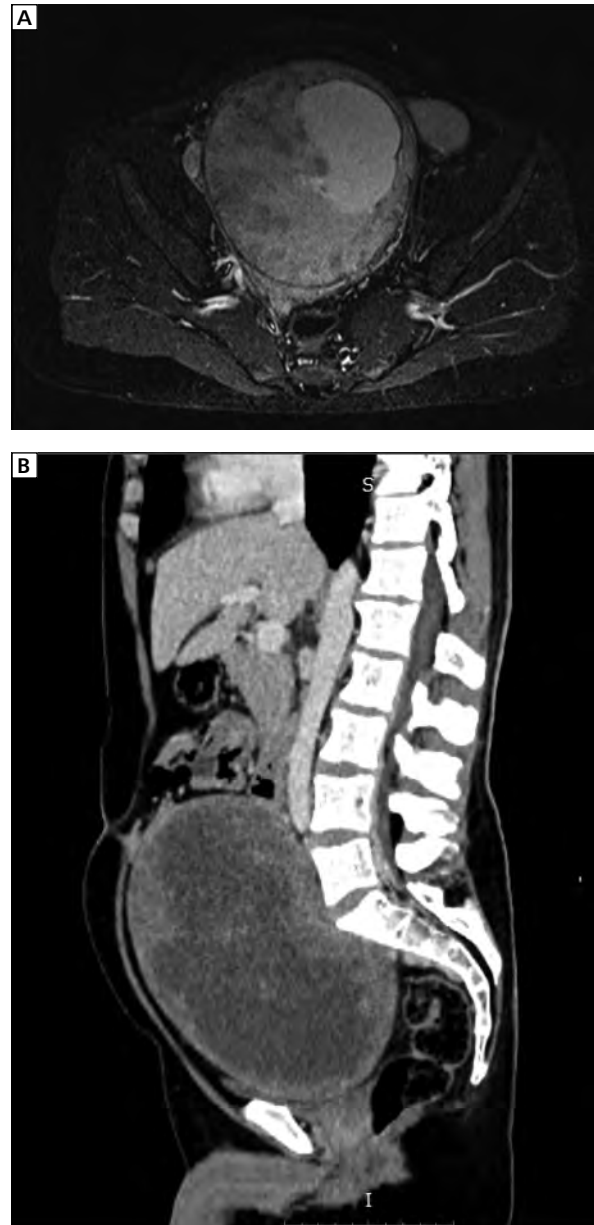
Magnetic resonance image of the pelvis MPNST (A) and reconstruction of the same sarcoma in the CT scan (B)
